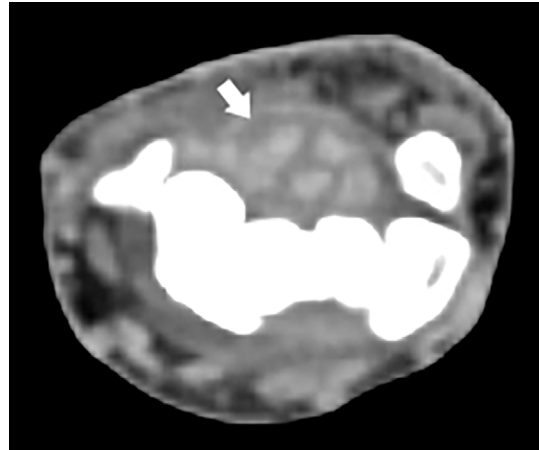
CT scan without contrast of the wrist showing edema around the digital flexor tendons at the wrist.
